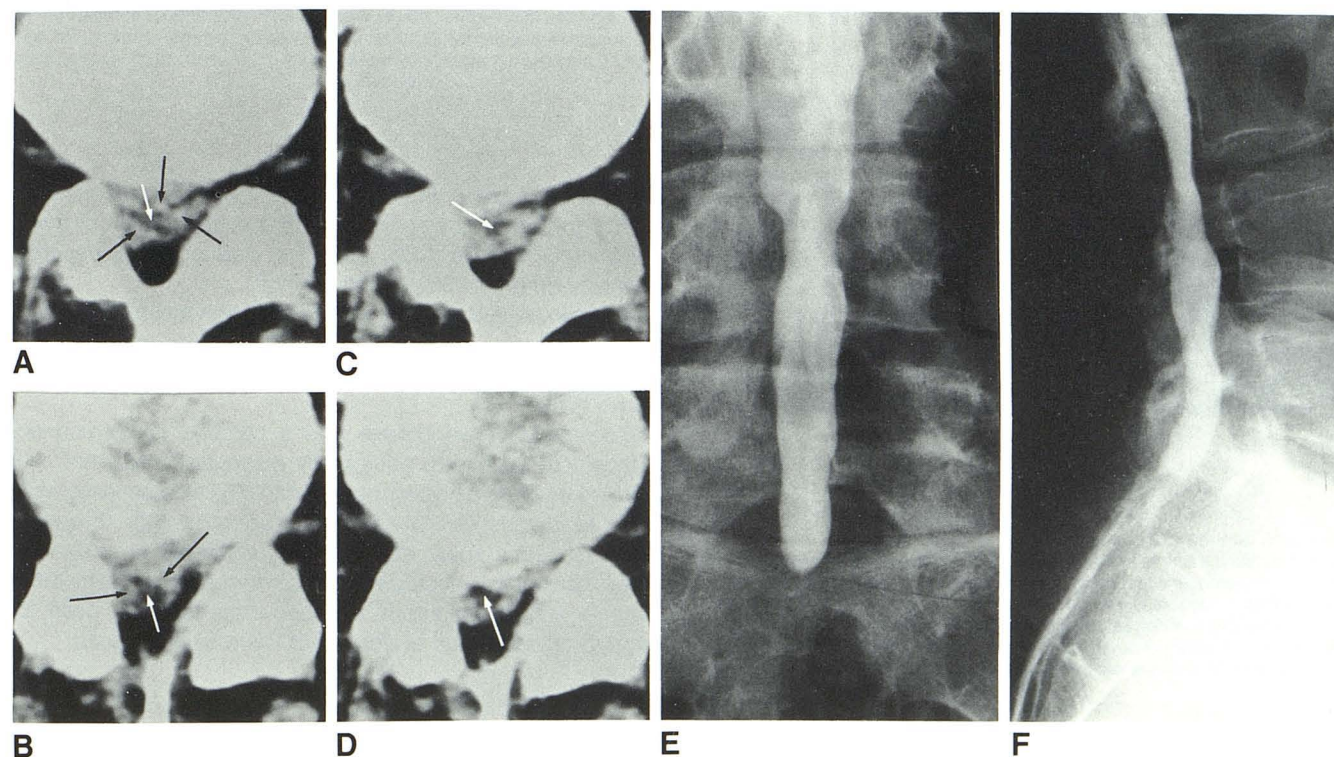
Postoperative arachnoiditis. A and B, Nonenhanced postoperative CT scans show small and somewhat irregular thecal sac (white arrows) surrounded almost completely by irregular thick scar tissue (black arrows). C and D, Enhancement sections. Scar tissue in wall of thecal sac enhances. E and F, Anteroposterior and lateral metrizamide myelograms show typical
